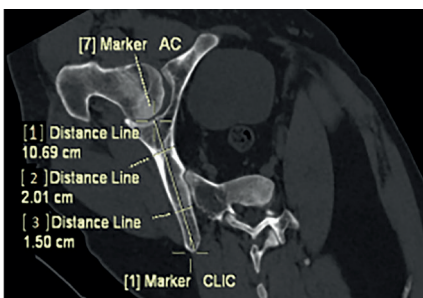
Path D [CLIC point to acetabular centre (AC)]. Double oblique reformatted CT image showing Path D trajectory; where [1] represents its length, while [2] and [3] represent width of its narrowest zones, [2] being anterior to [3].
